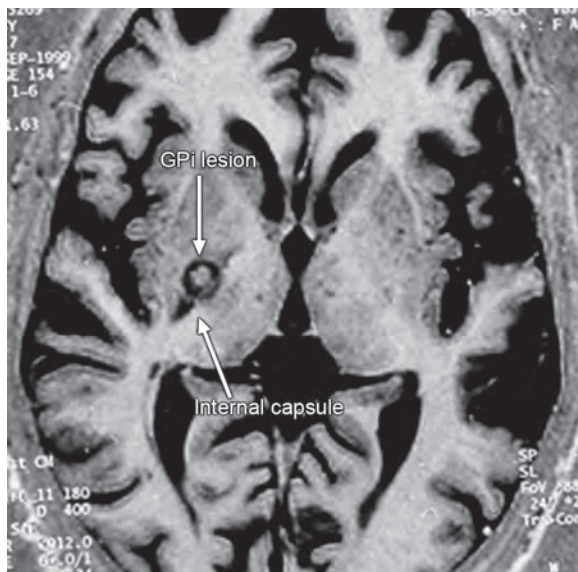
IR axial MRI showing GPI lesion (note the relationship with internal capsule)
